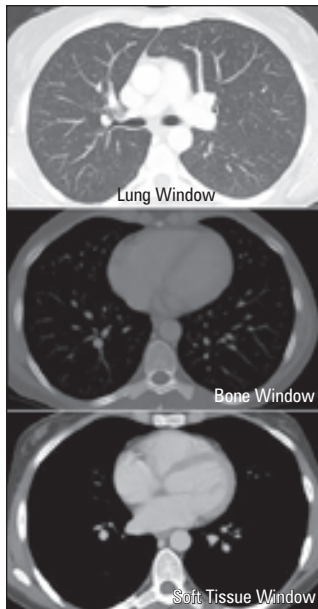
CT Thorax Windows
